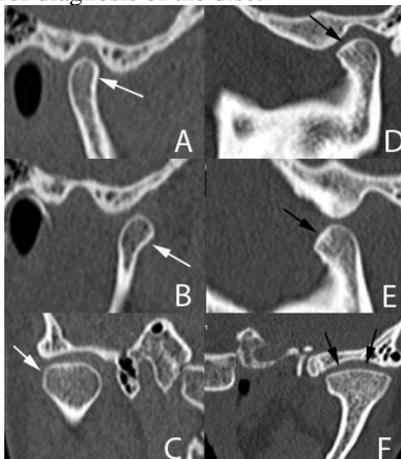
(Image Courtesy: Freire JSL, Barbosa JMN, Evaluation of bone changes in the temporomandibular joint using cone beam CT. Dentomaxillofacial Radiology. 2012;41:24-9).
